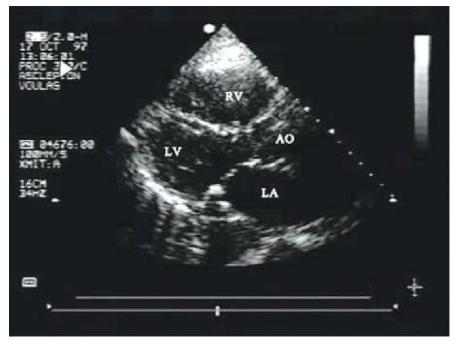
Parasternal long-axis view showing dilatation of the right ventricle secondary to acute pulmonary embolism. Ao, ascending aorta; LA, left atrium; LV, left ventricle; RV, right ventricle.
